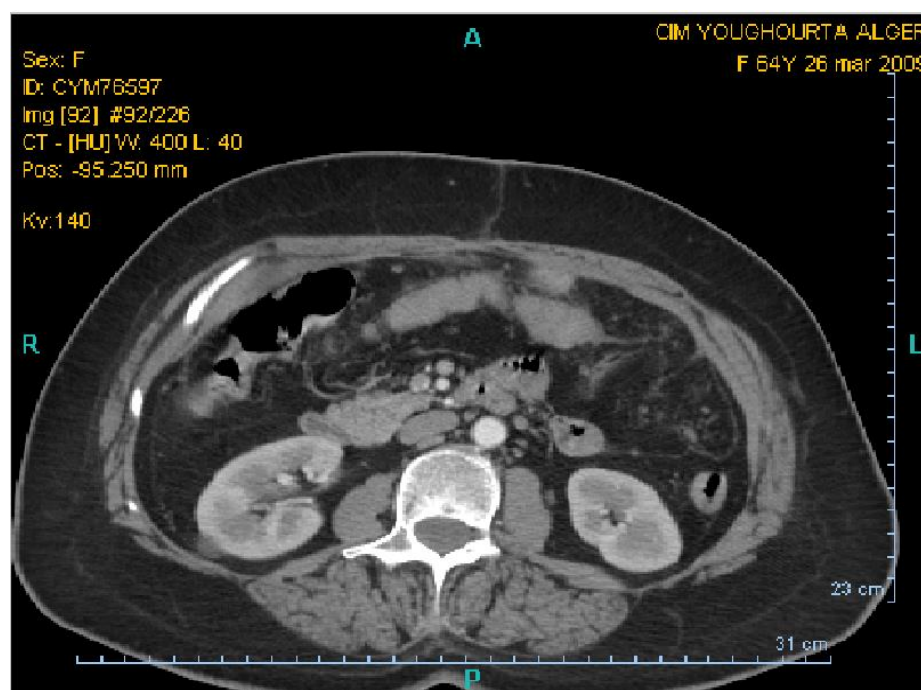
CT SCAN. Sub-mesocolic floor. Absence of lesion at 2 months postoperative (Case 2).
